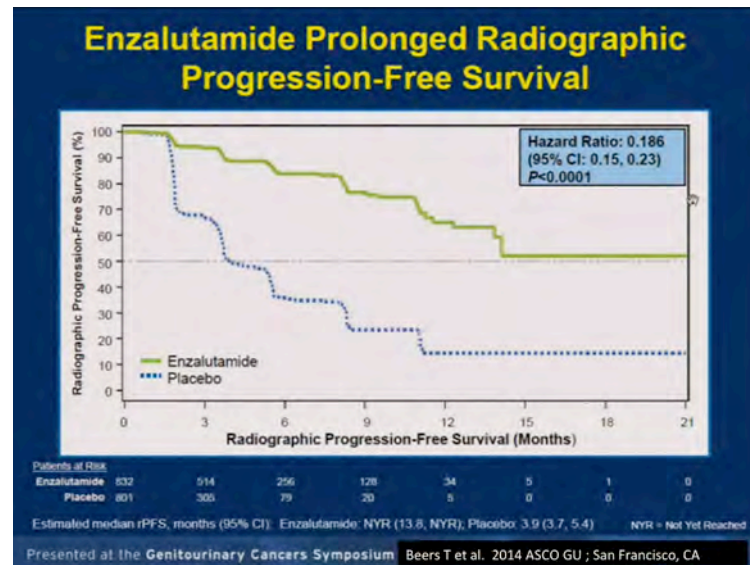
PREVAIL: Enzalutamide prolonged radiographic progression-free survival compared with placebo in pre-docetaxel mCRPC [84].
